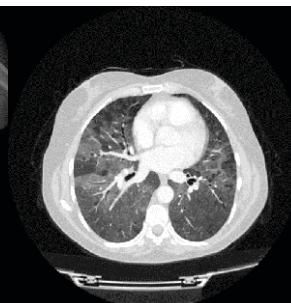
Chest CT scan (a year after COVID-19).
